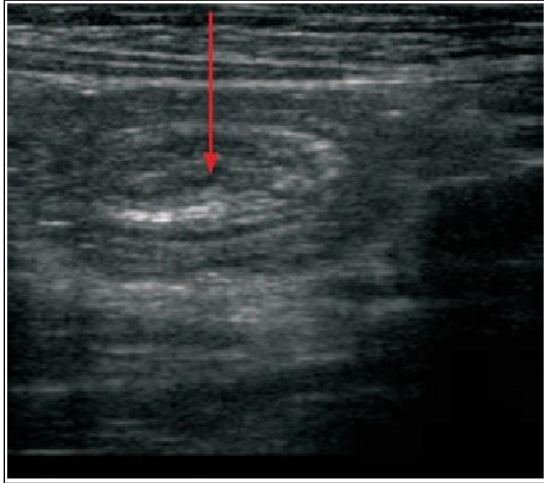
Ultrasound demonstration of Target sign/Donut sign.
